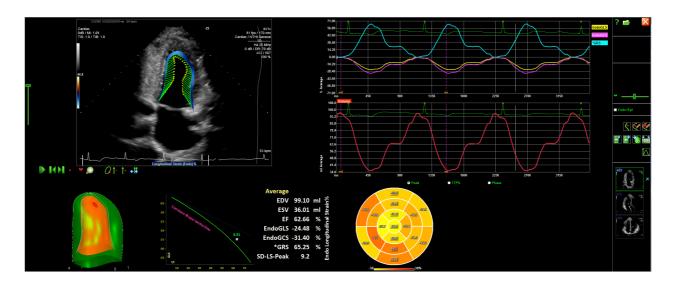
Snapshot of the graphical user interface of the software developed within the context of DOPPLER-CIP for efficient extraction of morphologic and functional data.
